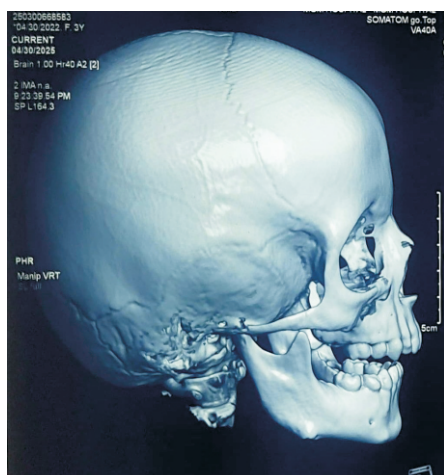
Three-dimensional CT lateral view showing an expansile lesion in the right mandibular angle with cortical expansion and thinning, and an intact inferior mandibular border.
